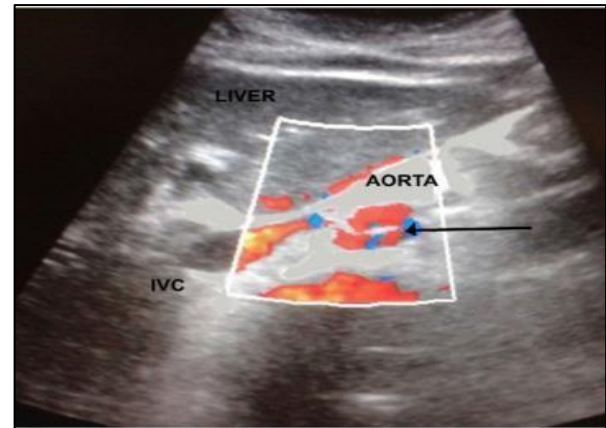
Colour Doppler image (axial section) showing aortic dissection in a case of hypovolemic shock in our study. The arrow shows the dissected intimal flap.
